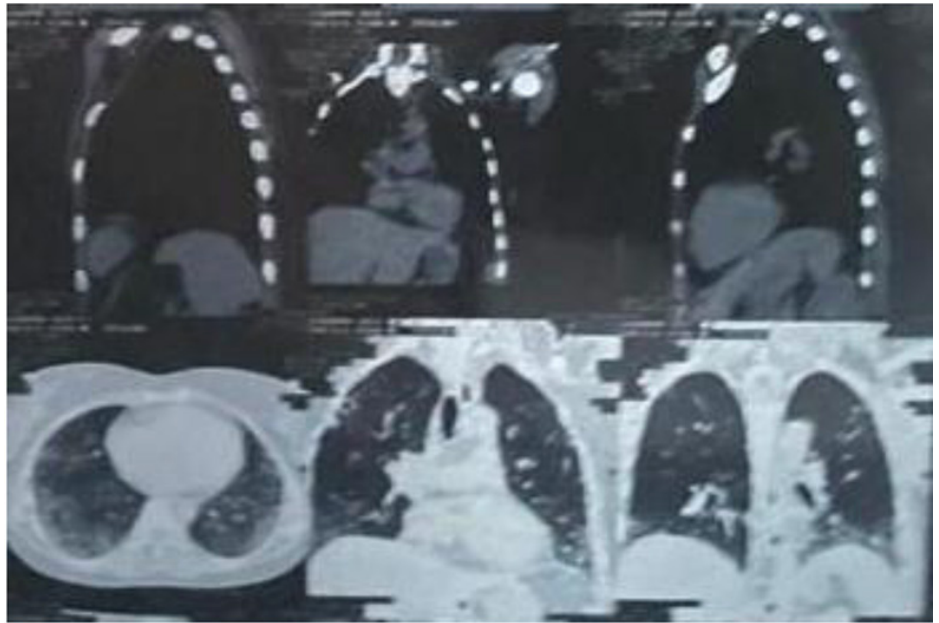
The non-contrast chest CT scan demonstrated ground glass opacity with interstitial thickening.
